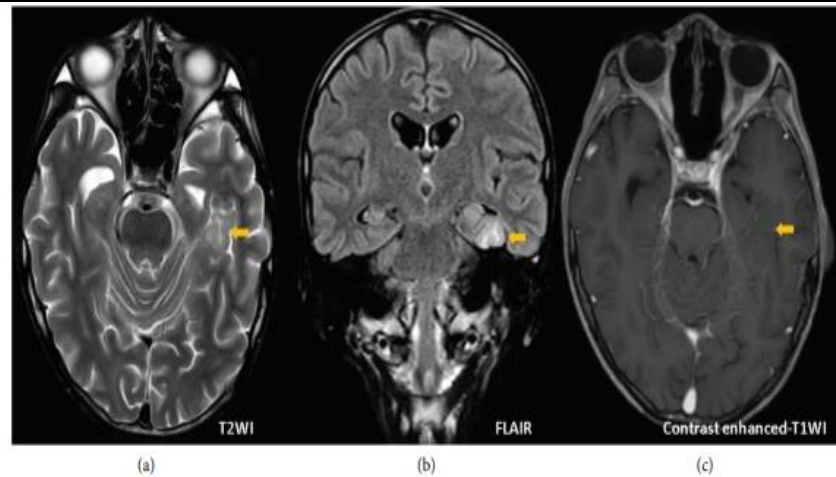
Six weeks following admission, a head MRI showing (a) T2-weighted, (b) FLAIR, and (c) contrast enhanced-T1 weighted (right).
